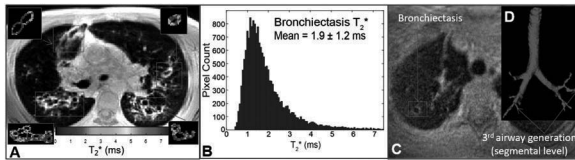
Optimizing UTE MRI to visualize bronchiectasis. A. Multi-echo UTE imaging to map T_2^* of bronchiectasis. B. Histogram of T_2^* values of the bronchiectatic airways of CF patients. C. Bronchiectasis in the right upper lobe of a 28-year-old female CF patient visualized by optimized, high resolution FLORET UTE. D. Segmented 3D airway from C, showing segmental-level resolution.
